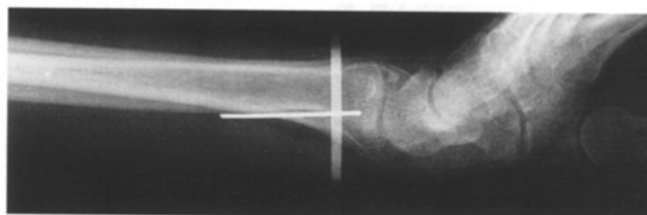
Conventional lateral radiograph of the distal radius. Compare with Fig. 6
